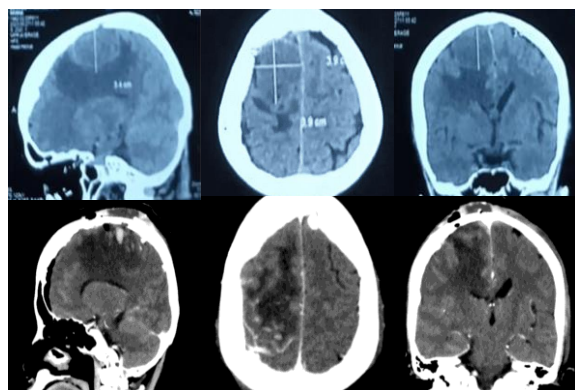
Pre-operative and post-operative non-contrast CT imaging comparison in sagittal, axial, and coronal views for case 6
